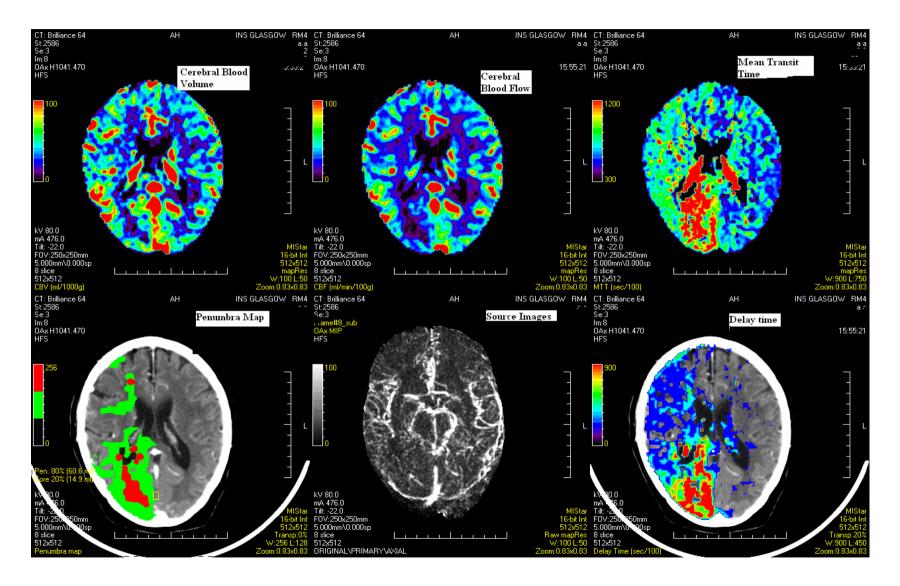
CT perfusion images from the POSH study
